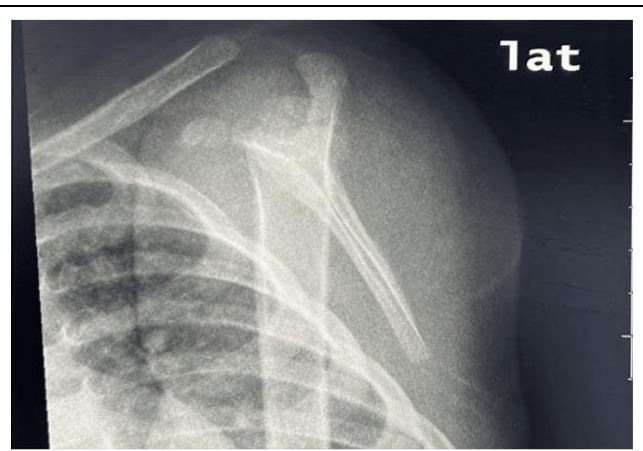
Left shoulder lateral scapula radiograph view revealed normal bony signals of the shoulder, scapula, clavicle, and proximal humerus.
